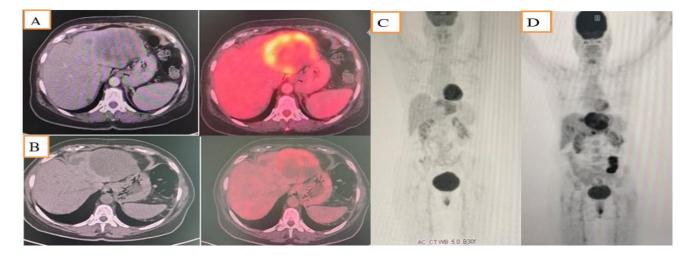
63 years old male patient with metastatic colonic cancer receiving chemotherapy. (A) Pre-therapy CT and Fused FDG PET/CT images & (D) Pre-therapy MIP images shows large left hepatic lobe lesion at segment II measures 9.2x7.6 cm with SUVmax~15.4, Peak~12.8 TLG~670 and MTV~85.8. (B) Post-therapy CT and Fused FDG PET/CT images & (C) Post-therapy MIP images show significant regression in metabolic activity reaching SUVmax~6.5 Peak~4.3 TLG~162 and MTV~68.3, with mild size regression measuring 7.2x8 cm.
